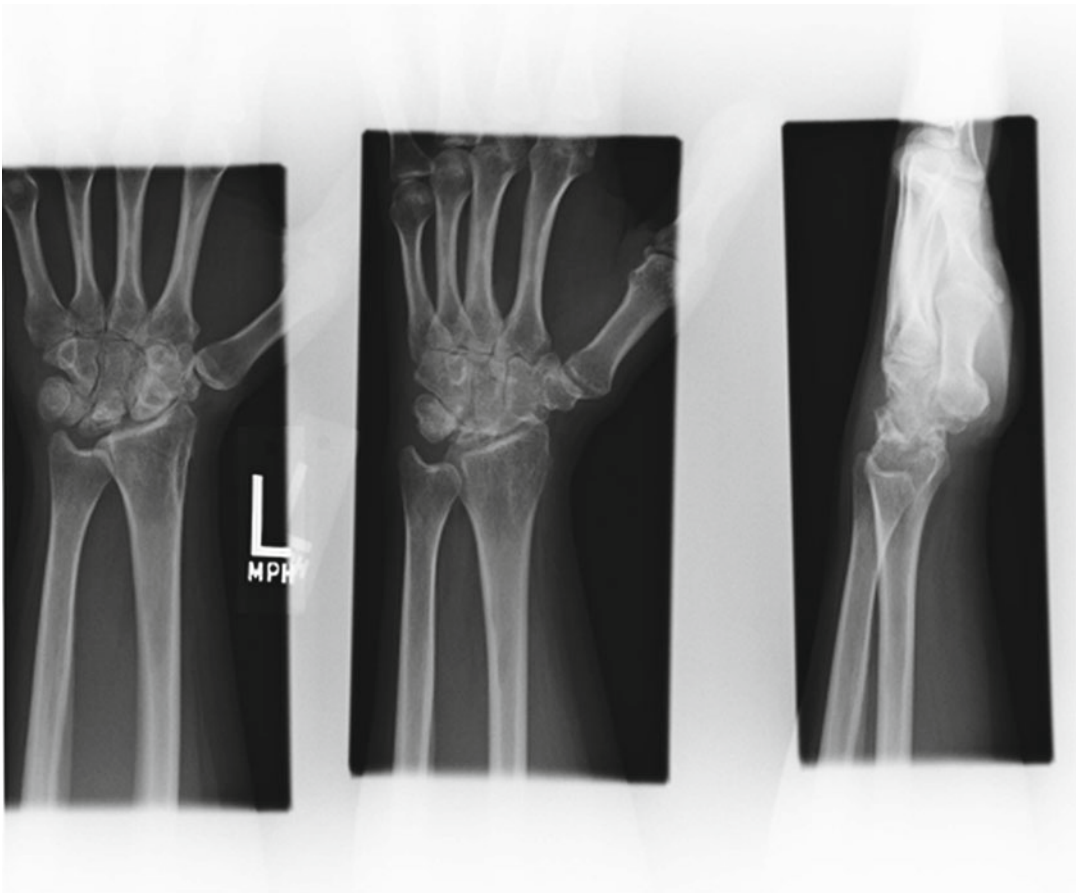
Postoperative: PA, oblique, and lateral radiographs of the L wrist 18 months s/p STT fusion for Kienböck's disease, Lichtman stage 3b. The fragmentation of the lunate that exists at the time of limited wrist
